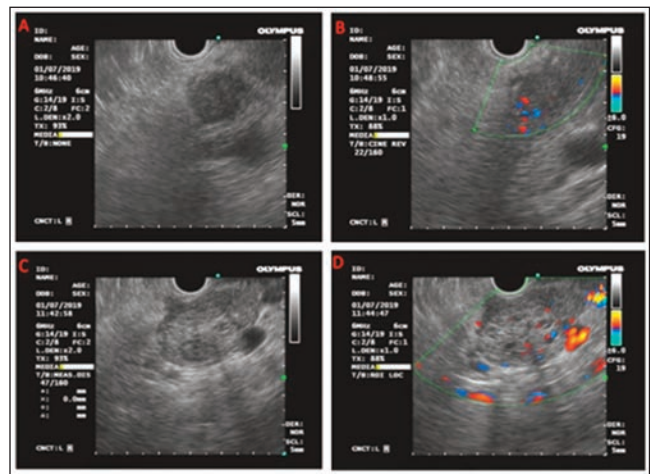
The findings on endoscopic ultrasonography are shown. A low echo lesion and a high echo focus, with cross-sectional areas of 18.2x18.9 and 18.9x23.5 mm², respectively, were identified in the pancreas. Multiple low-echo foci with clear boundaries were also detected.
